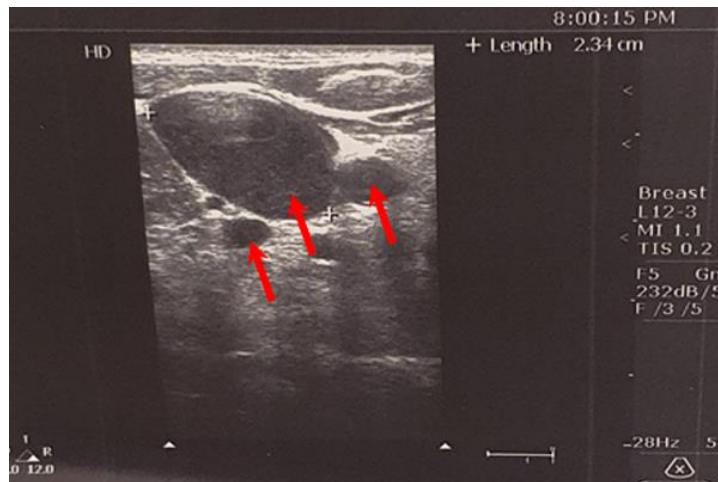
Echsonographic examination of the thyroid gland and soft tissues of the neck - Enlarged lymph glands with a largest diameter of 23 mm on the right side of the neck
